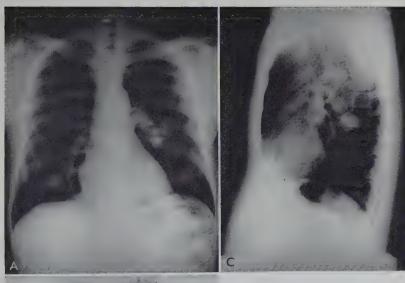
A, Nodular lesion inferior to left hilum. B, Anteroposterior lung scan appears normal. C, Lateral roentgenogram of chest demonstrates nodular lesion as in the apical segment of the left lower lobe. This lesion was located too far posteriorly for the lung scan to demonstrate it from the anterior view, since it was out of range of the focus of the collimator for the scintillation scanner.
